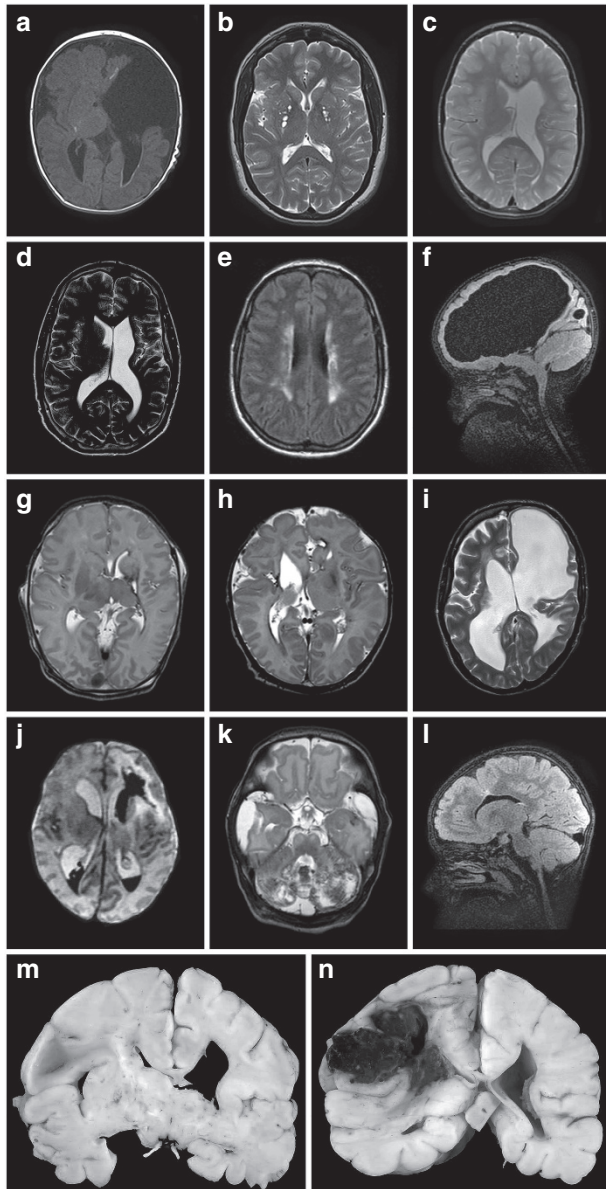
Selection of brain magnetic resonance images of novel patients. (a) T1-weighted image of patient A-II.1 showing porencephaly with cortical destruction and white matter hyperintensities suggesting calcifications and/or hemorrhage. (b) T2-weighted image of patient A-I.2 showing enlarged perivascular spaces. (c,d) T2-weighted images of patients B-III.1 and B-II.1, with classic left-sided unilateral porencephaly. (e) Fluid-attenuated inversion recovery (FLAIR) image of patient C-II.1, indicating periventricular leukomalacia. (f) FLAIR image of patient D-II.1 depicting severe expansive porencephaly and severe white matter loss. (g) T2-weighted image of patient E-II.1 with left-sided hemorrhage with ipsilateral volume loss of white matter, thalamus, and basal ganglia. (h) T2-weighted image of patient H-II.1 showing right-sided schizencephaly and porencephaly and a small hemorrhage in the left frontal lobe. (i) T2-weighted image of patient J-II.1 with left-sided porencephaly with bilateral ventricular enlargement and leukoencephalopathy. (j) T2-weighted image of patient K-II.1 with a left-sided germinal matrix hemorrhage leading to intraventricular hemorrhage and a left-sided venous infarction. (k) T2-weighted image of patient L-II.2 depicting bilateral severe cerebellar hemorrhage in both hemispheres. (l) FLAIR image of patient M-II.2 showing closed-lip schizencephaly and focal cortical dysplasia. (m,n) Postmortem images of patient E-II, showing ventricular dilatation and a large intraparenchymal hemorrhage.
